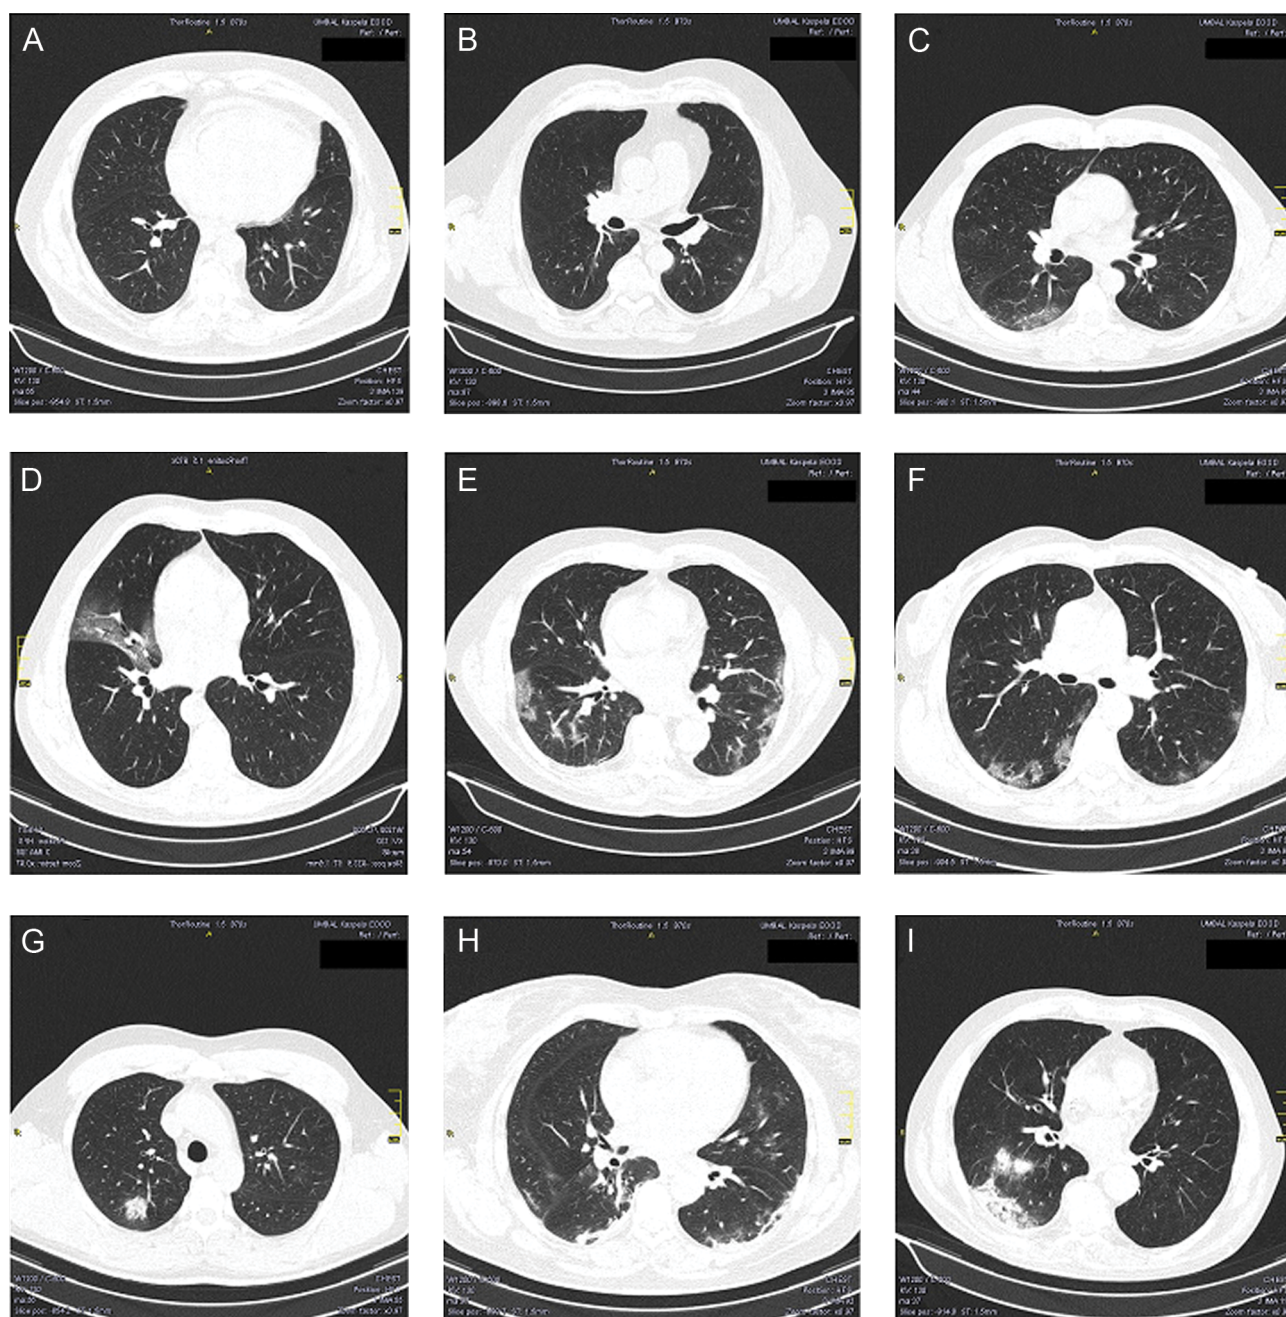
CT slices of the lung window in different cases with COVID-19 pneumonia. A. Patient with no imaging findings; B. A small ground-glass opacity is seen in the left lung - CO-RADS 3 changes, later confirmed with PCR test; C. Low density ground-glass opacity in the right lung - COVID-19 pneumonia, initial stage; D. Ground-glass opacity in the left lung - mild COVID-19 pneumonia; E. Ground-glass opacities in the periphery of both lungs - COVID-19 pneumonia, 7 days; F. Ground-glass opacities in the periphery of both lungs - mild COVID-19 pneumonia, duration 10 days; G. Oval dense ground-glass opacity in the right lung - COVID-19 pneumonia, 14 days; H. Diffuse interstitial thickening in the periphery of both lungs - COVID-19 pneumonia, duration 14 days; I. Diffuse infiltrate in the 6th segment of the right lung - COVID-19 pneumonia, duration >14 days.
